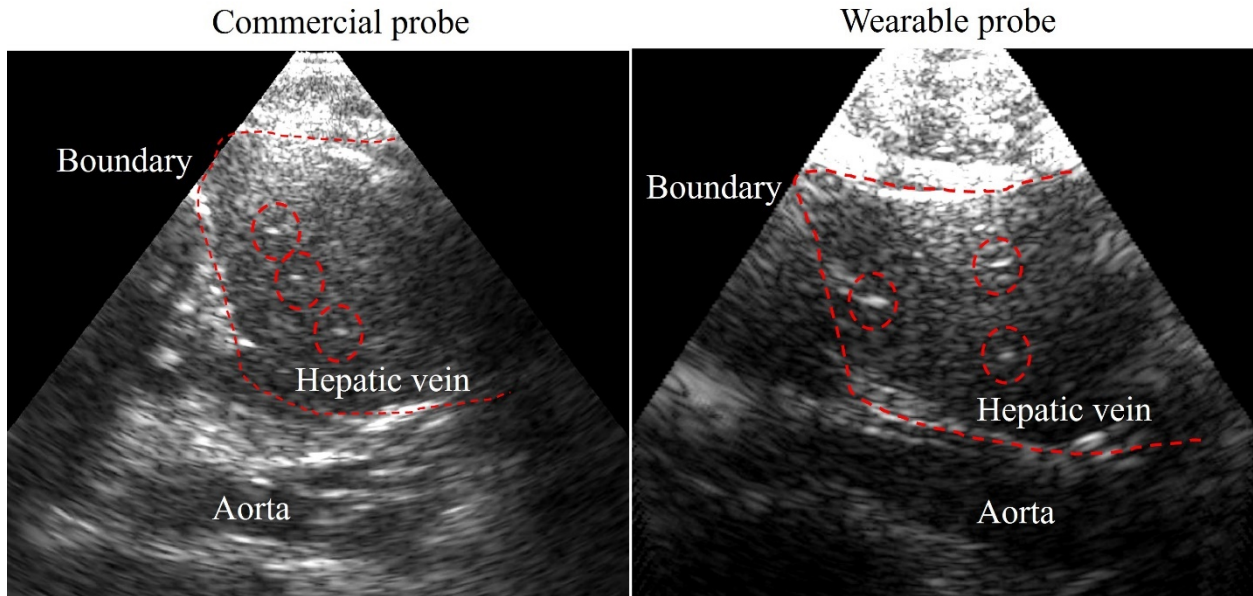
B-mode images of abdominal aorta from longitudinal view from both commercial and wearable ultrasonic probes.
